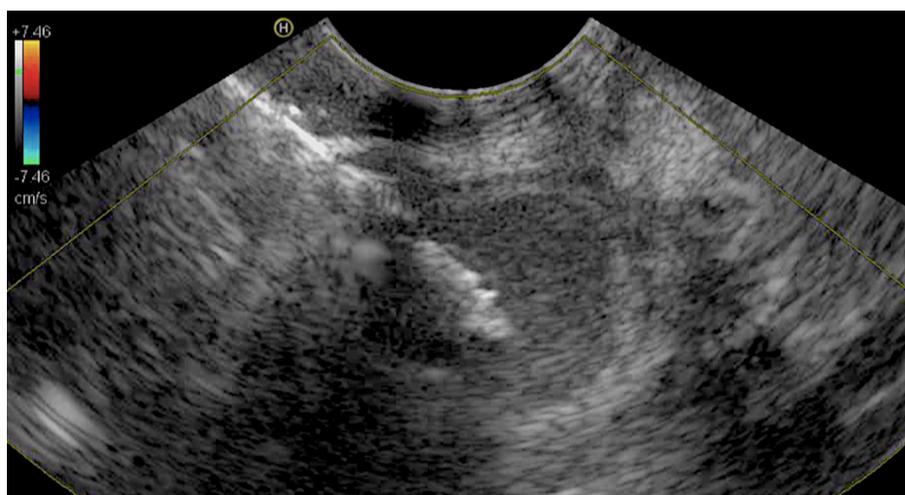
Endoscopic ultrasound guided wound of the gallbladder through the duodenal bulb.
